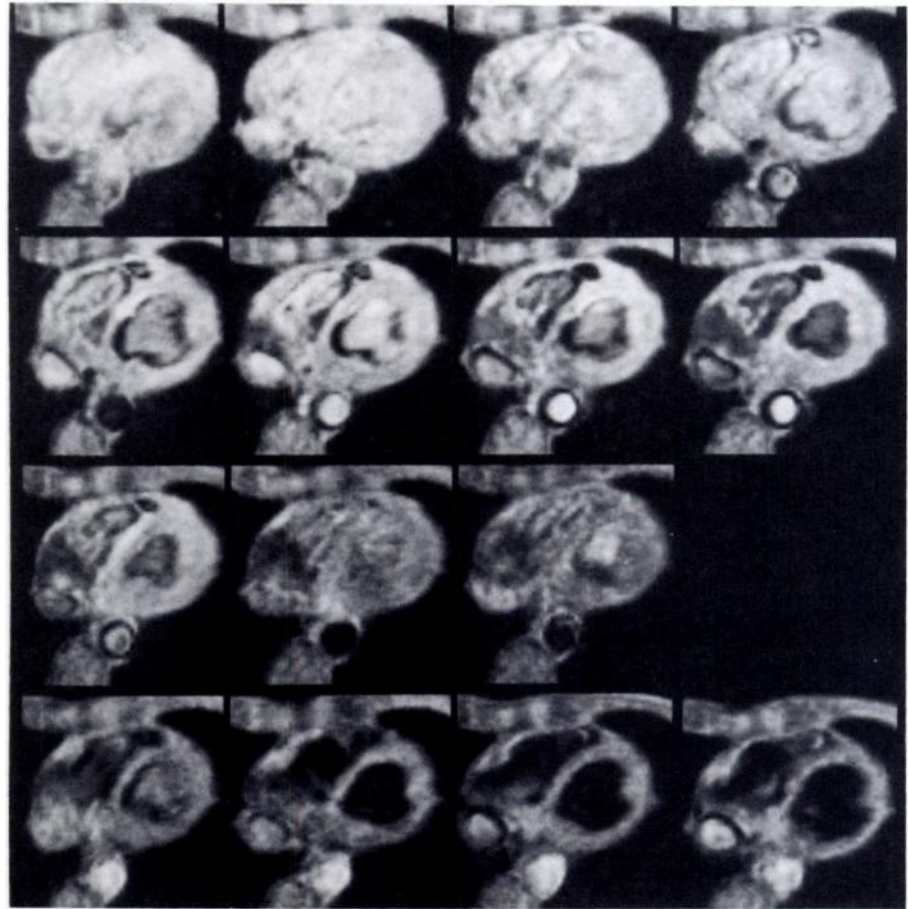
Sequence of cine cardiac MR images obtained at 0.05 T. Images from eight cardiac levels with 16 time points per beat, 30 msec apart, are obtained in 20 minutes and are displayed in a cine mode. Such cine MR images provide both anatomic and functional information.
